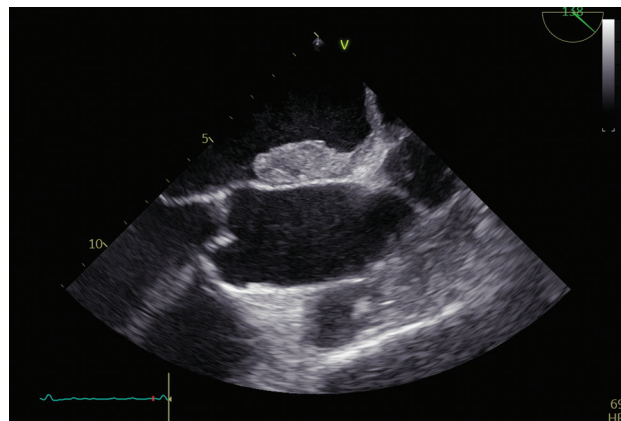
138-degree view transesophageal echocardiography image showing an oval homogeneous left atrial mass.
